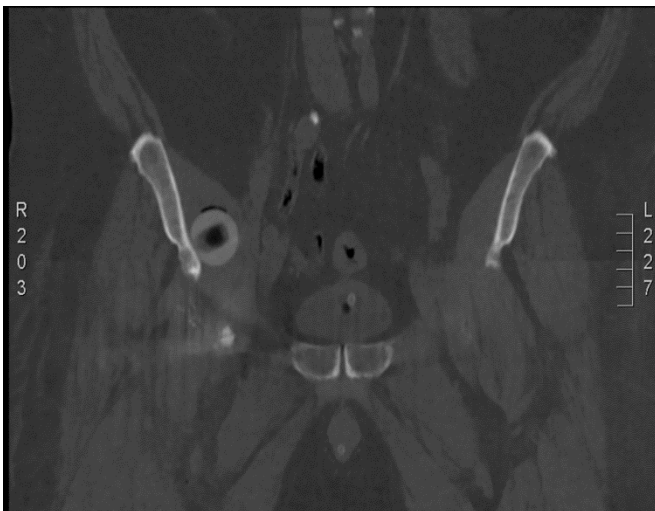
Coronal CT scan section shows trial femoral head
